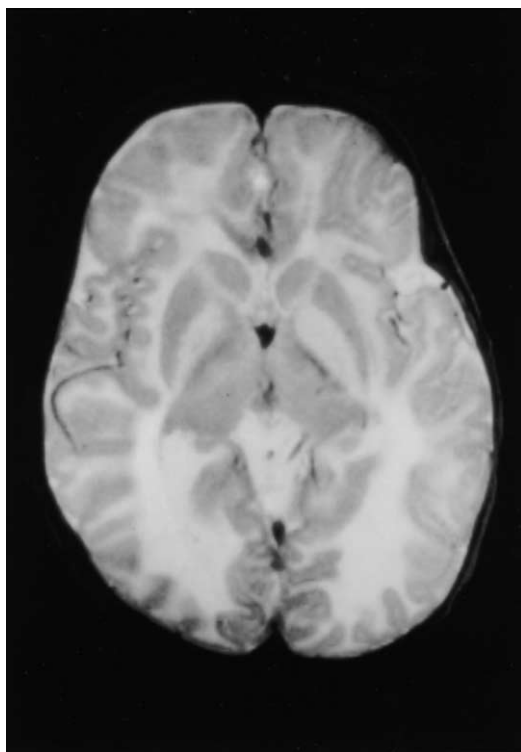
MRI study of the brain of a 9-month-old child with Canavan disease, showing diffuse white matter disease involving the sub cortical regions, the posterior fossae, and the internal and external capsules are more severely involved.
